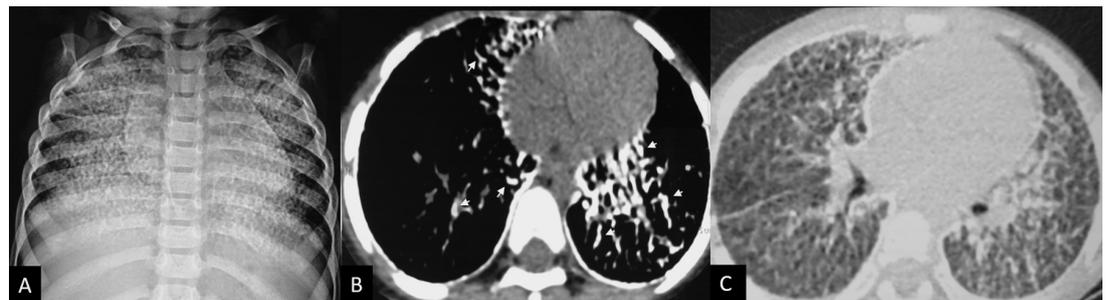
Chest radiograph showing dense reticulonodular opacities in bilateral lungs (A). HRCT soft tissue (B) and lung (C) window confirming high-density linear areas of calcification (arrows) in bilateral lungs predominantly in posterior location suggestive of alveolar microlithiasis. HRCT, high-resolution CT.
